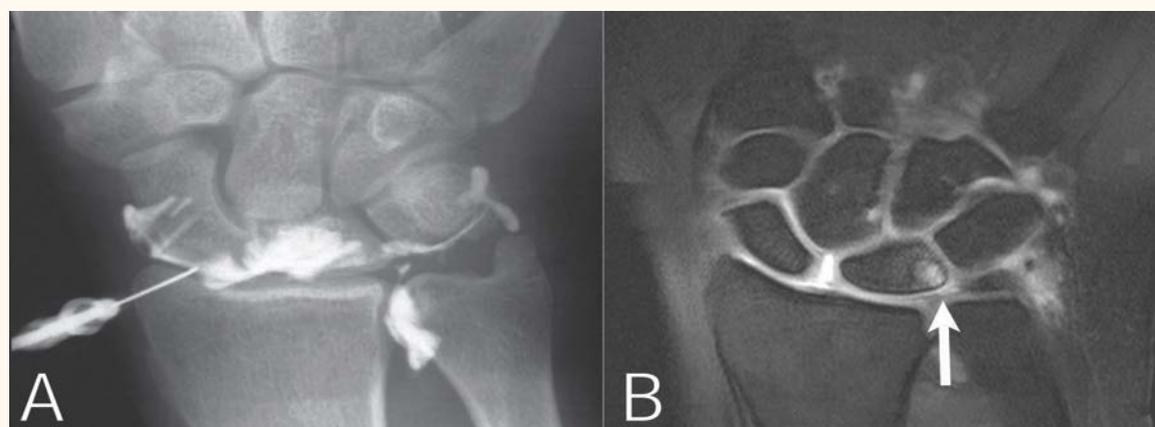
(A) Radiocarpal wrist arthrography showing a tear at the pararadial part of the triangular fibrocartilage complex (site 2); (B) Coronal T1-weighted fat-saturated sequence confirming the arthrogram finding and clearly showing the tear (arrow).
